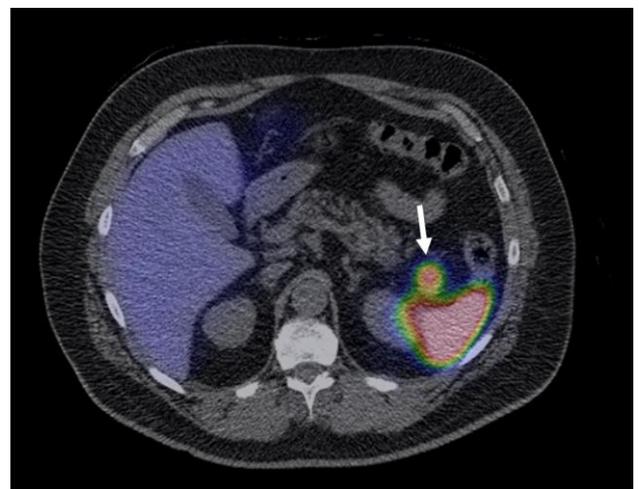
Tc-99m heat-damaged red blood cell scintigraphy with SPECT showing focal radiotracer accumulation in a pancreatic tail lesion (arrow), with uptake matching that of the spleen, consistent with intrapancreatic accessory spleen.
